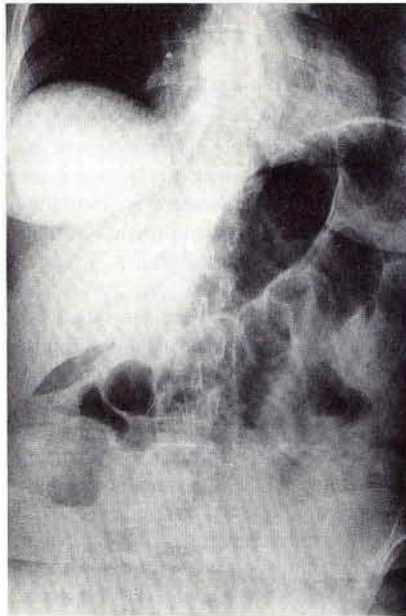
Twelve hours after a diagnostic colonoscopy in a 52-year-old woman, the radiograph showed loops filled with fluid and gas in the small intestine, indicating small-bowel ileus, and an air-filled colon.
